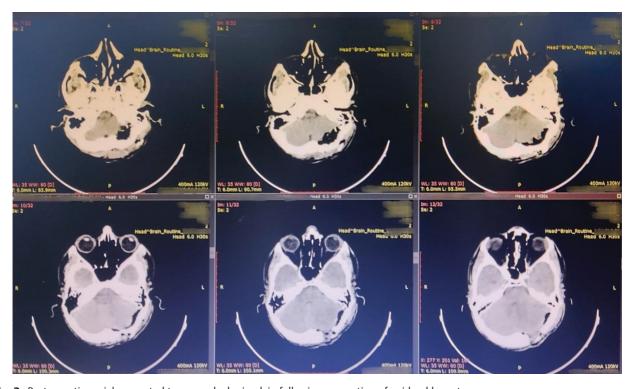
Postoperative axial computed tomography brain plain following evacuation of epidural hematoma.
